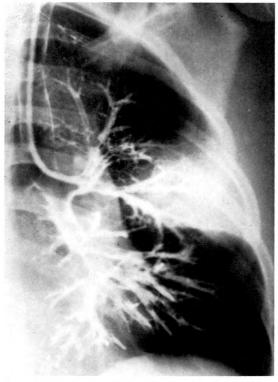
This 14 year old boy presented with a history of severe hemoptysis of 2 weeks' duration. A chest roentgenogram revealed consolication of the anterior segment of the right upper lobe. A vascular sarcoma had been resected from the left scapular area I year previously. At bronchoscopy, bleeding from the orifice of the left upper lobe bronchus was noted. The segment was selectively catheterized. the area was irrigated with Ringer's solution, and the aspirate retained for cytologic and bacteriologic examination. Examination of the aspirate revealed only red blood cells. Following irrigation, selective and routine bronchography was performed, using the same catheter. Patent segmental bronchi were demonstrated, At thoracotomy, the surface of the lung was studded with small, hemorrhagic, tumor nodules; there was extensive hemorrhage into the parenchyma of the anterior segment.
